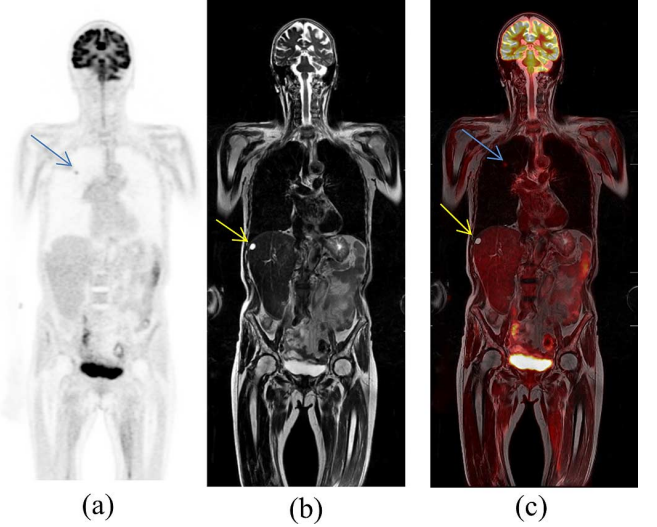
Coronal whole-body images of the second subject with lesions in lung and liver regions as pointed by the arrows. Shown are (a) PET image from TOF PET/MR system; (b) MR coronal image; and (c) co-registered PET+MR images.
